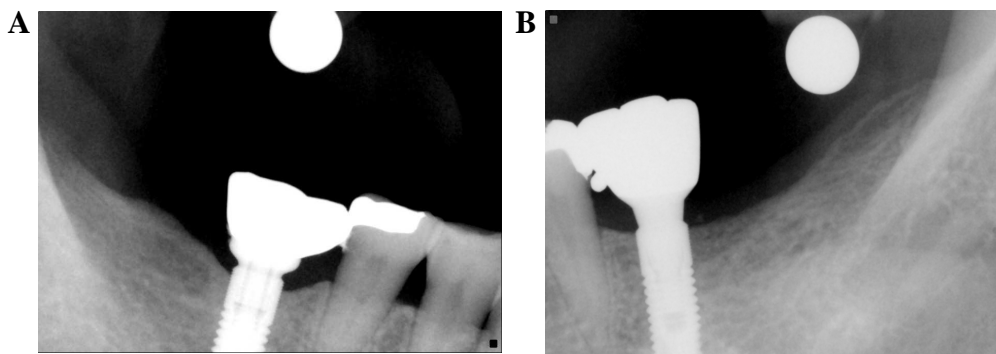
Periapical radiograph of the patient who had both exposed and non-exposed implant (lower right molar : exposed, lower left molar : non-exposed) (A, B) periapical view at suprastructure insertion.
